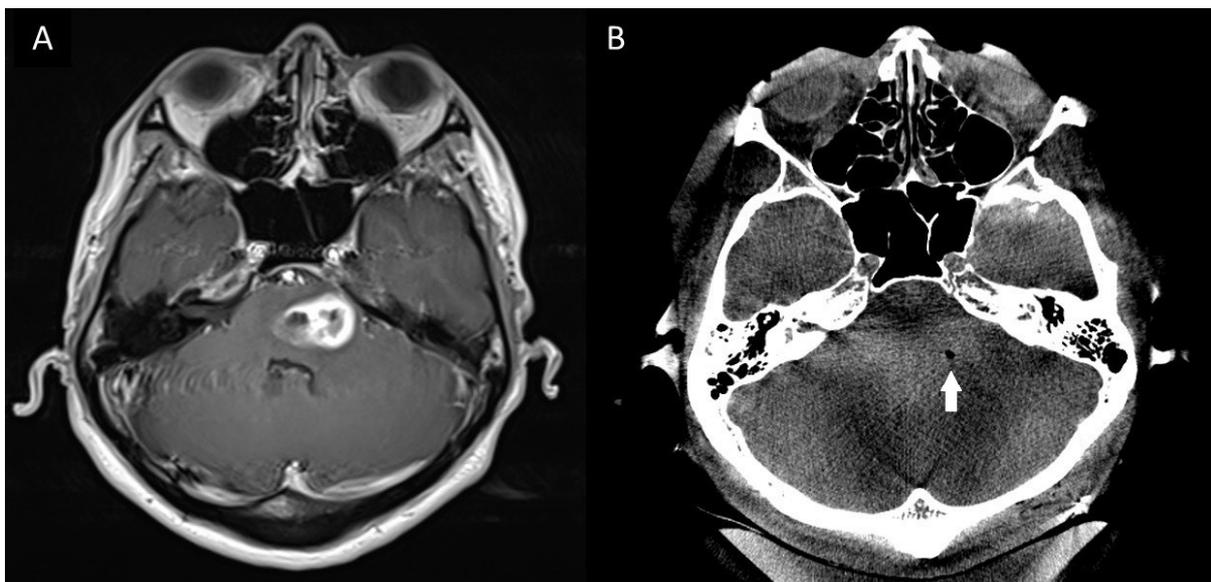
(A) MRI brain demonstrating a left hemipons peripherally-enhancing lesion; (B) intraoperative cone-beam CT demonstrating no iatrogenic haematoma and pneumocephalus (white arrow) at biopsy site.
